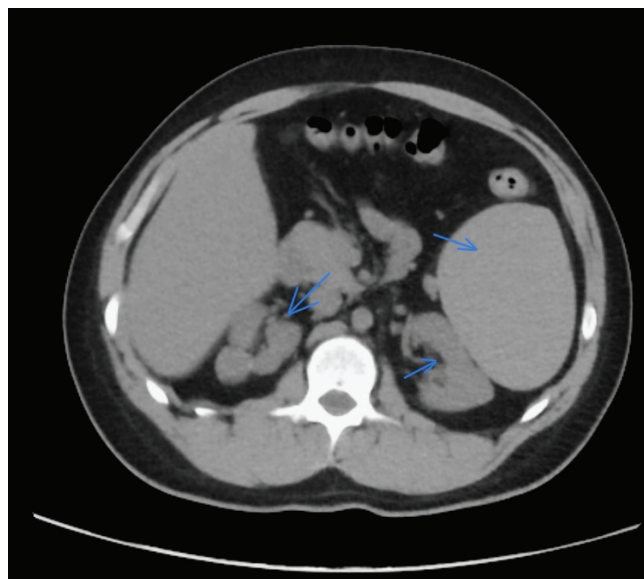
Computed tomography scan of the abdomen shows bilateral renal atrophy and splenomegaly (blue arrows).
